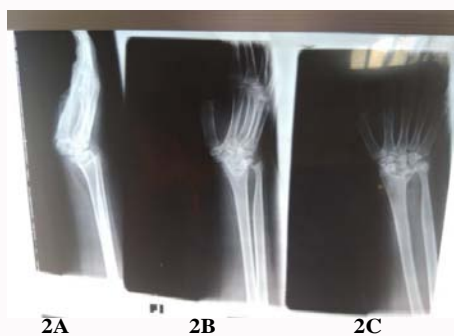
Lateral radiograph of the left wrist.
